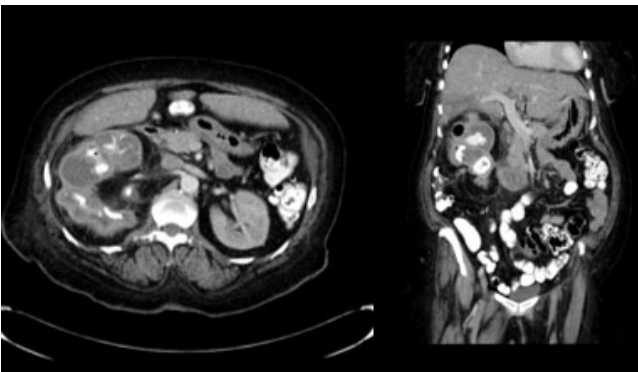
CT scan showing xanthogranulomatous pyelonephritis (XGP) kidney.
